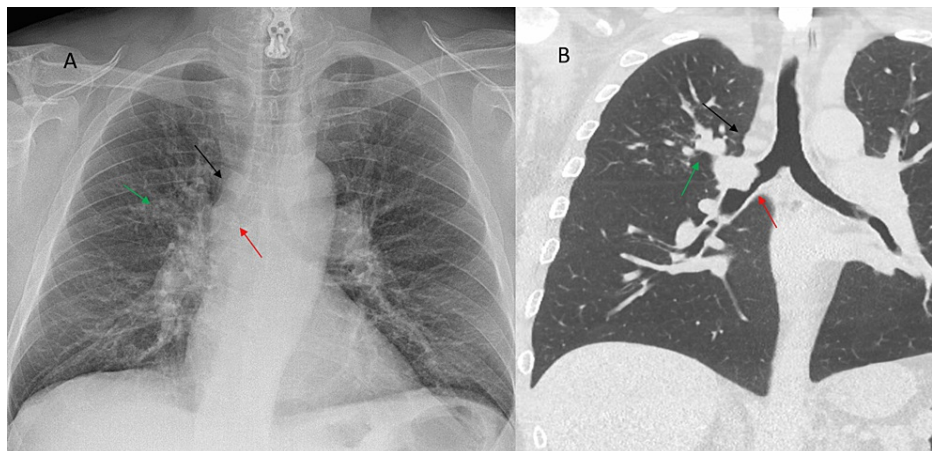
Last chest X-ray realized (A) and corresponding CT section (B).
